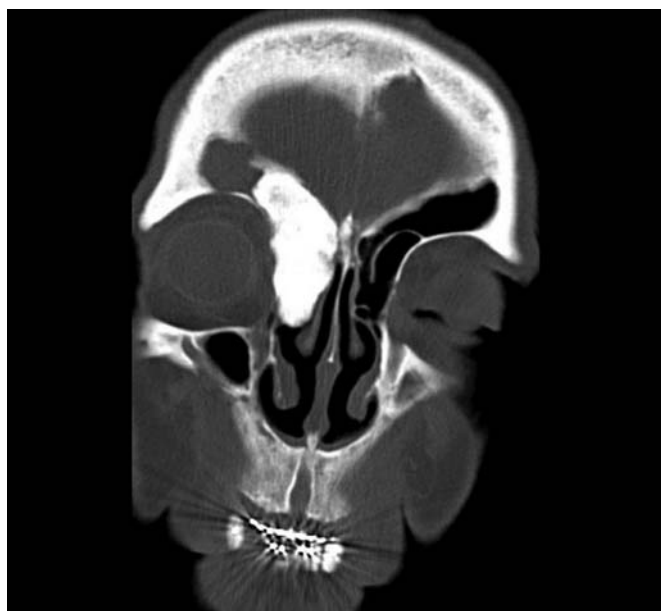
Coronal CT showing osteoma in the right nasal cavity.
